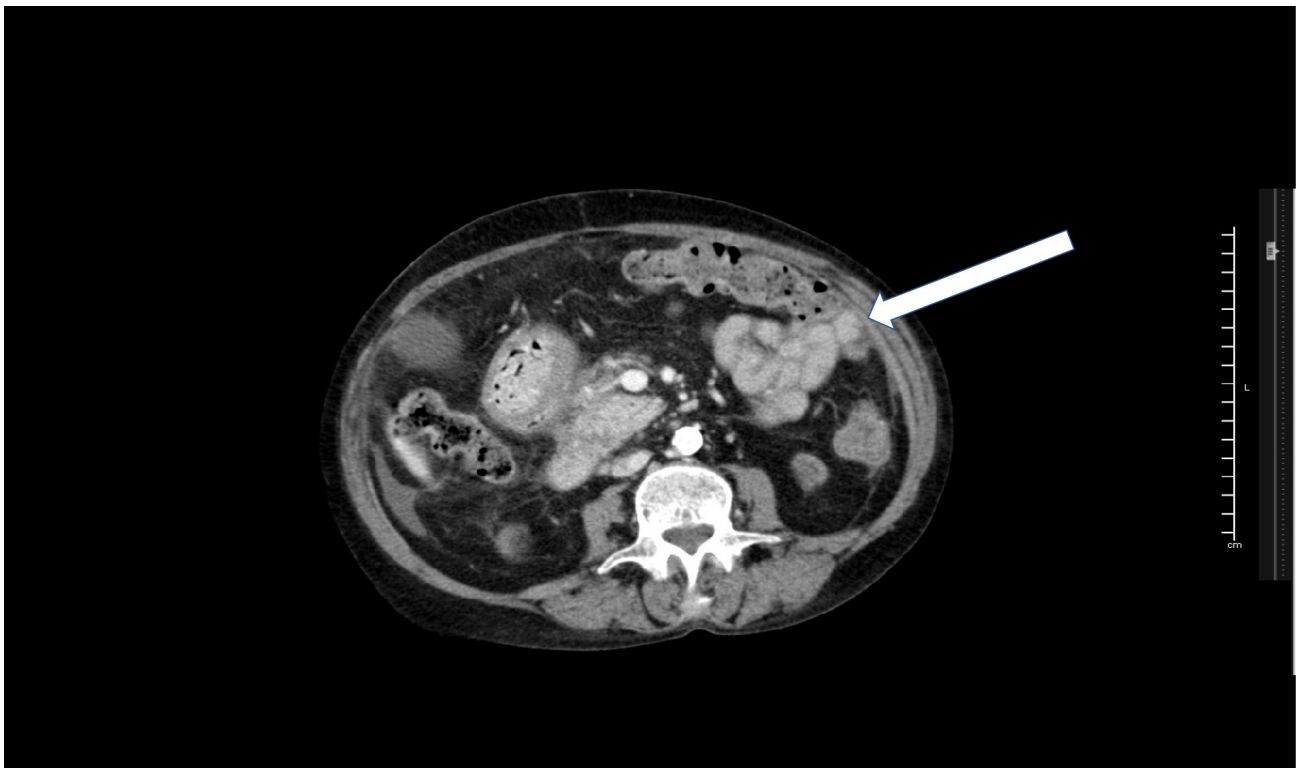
Abdomen contrast-CT showing adherent and conglomerate intestinal loops (white arrow).
